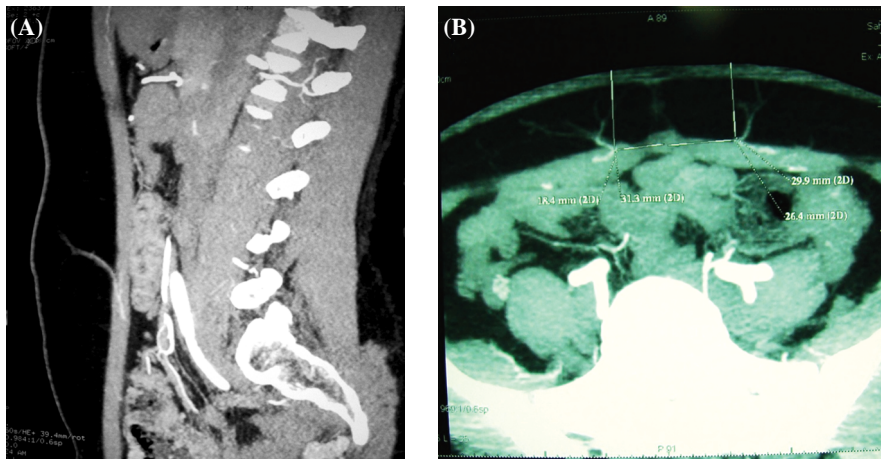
(A) Sagittal CT angiography image showing the course of the deep inferior epigastric artery perforators through the rectus muscle and fat. (B) Axial CT angiography image showing different perforator sizes.
